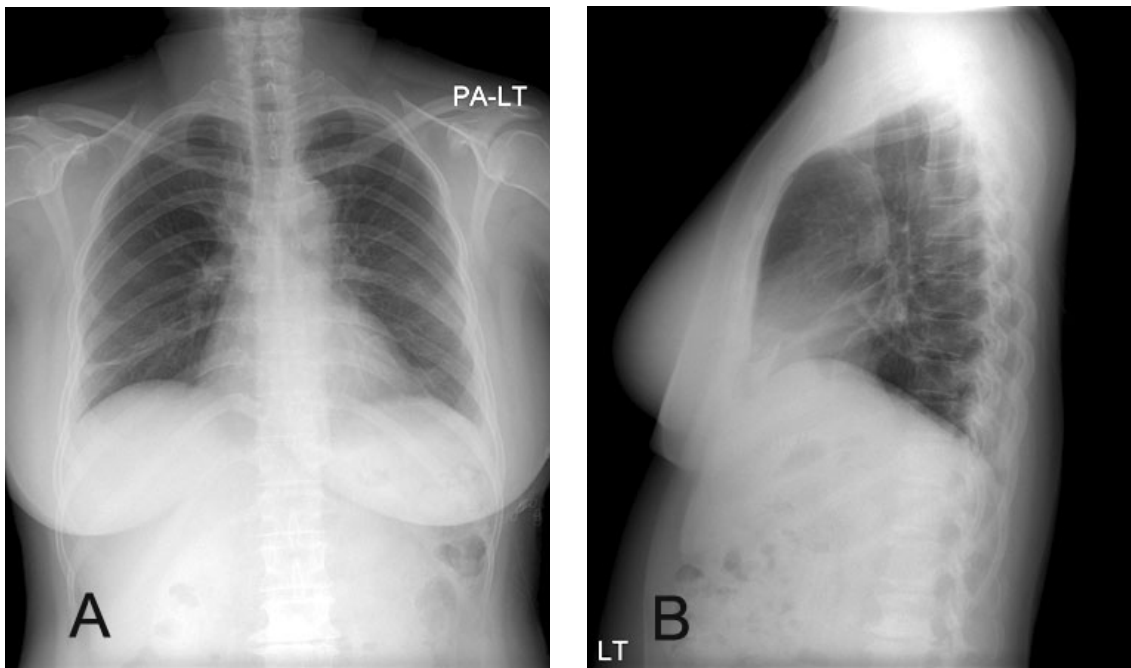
Post-operation chest PA (A) and lateral radiograph (B) shows normal.
